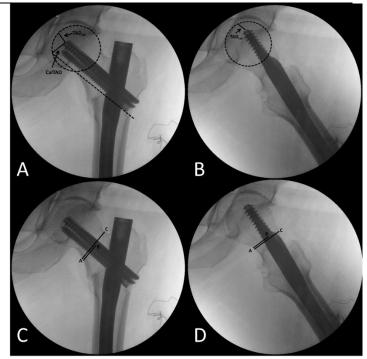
Radiographs demonstrated how the measurements were made. TADAP and CalTAD measurement (A) on the anterior-posterior view, TAPLat measurement (B) on the lateral view, ParkerAP (AB/AC) (C), and ParkerLat (AB/AC) (D) measurement on the anteroposterior and lateral views.
